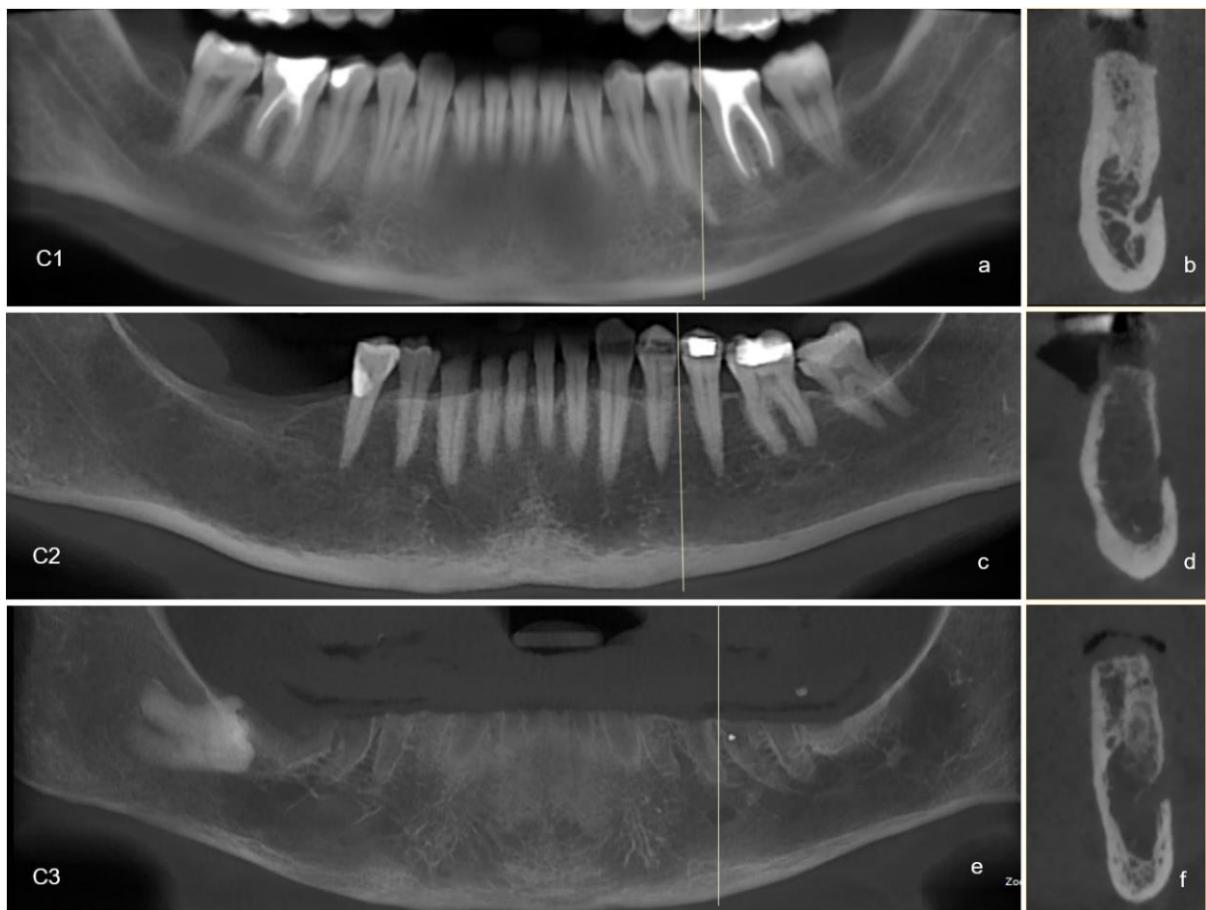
Scheme of the three-dimensional evaluation of the cortical quality (3D MOI CQ) using CBCT panoramic (a, c and e) and cross-sectional (b, d and f) reconstruction images and classified as: C1 (a and b), C2 (c and d) and C3 (e and f).
